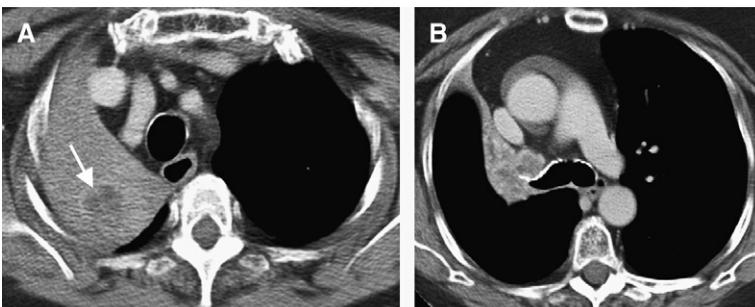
A 79-year-old woman with non-small cell carcinoma. Patient with advanced, symptomatic lung cancer. (A) CT scan demonstrates a 3-cm right lung tumor within right upper lobe collapse (arrow). (B) Central hilar adenopathy (N2) with occlusion of the right upper lobe bronchus. MR image of brain (not shown) also detected a metastasis (M1 disease).
